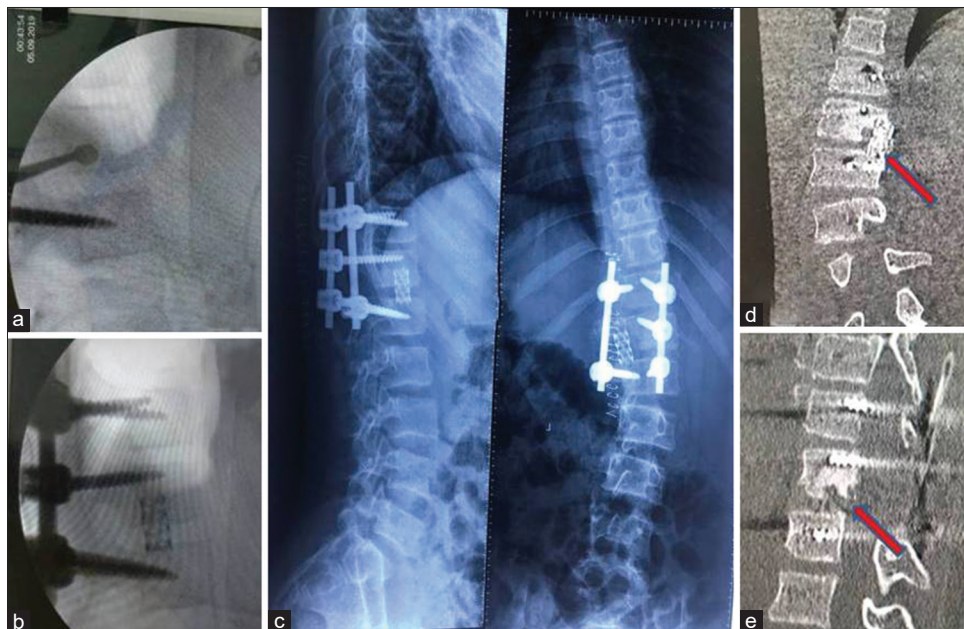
Intraoperative fluoroscopy images showing curette and cage placement (a and b). Postoperative posteroanterior and lateral radiographs showing a slight improvement in the alignment of the spinal curvature with implants in place (c). Postoperative reformatted coronal and sagittal computed tomography images (red arrows) confirming the excision of the lesion (d and e)
